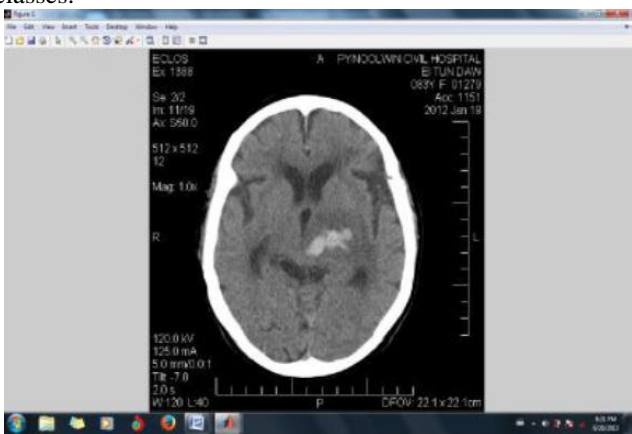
Original CT image
